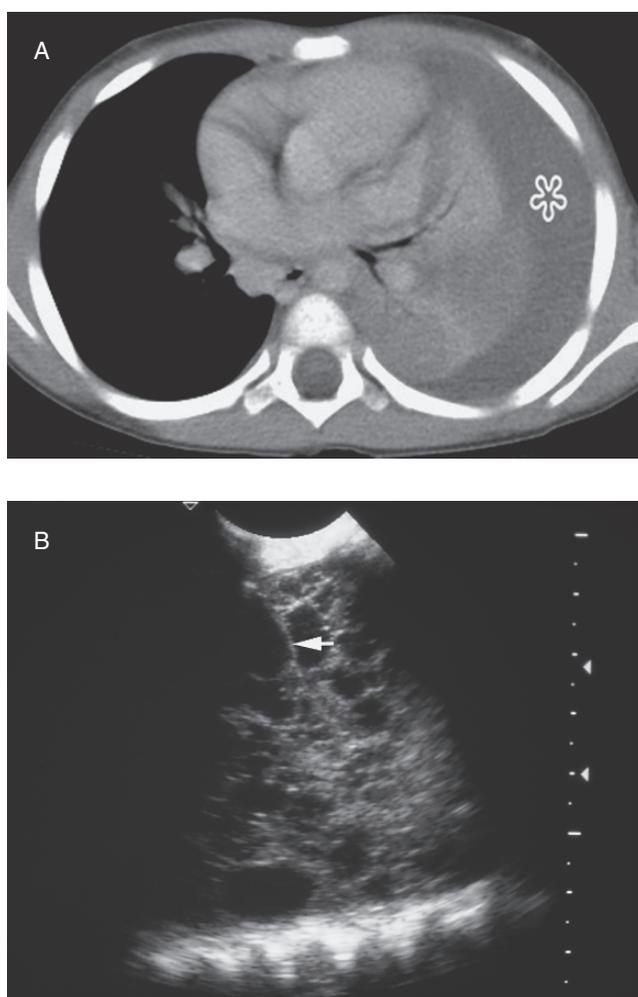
Percutaneous treatment of organized empyema. (A) Chest CT demonstrates left lower lobe pneumonia with large left pleural empyema (asterisk). (B) Sonogram of the left pleural empyema demonstrates grade 2 organization with large amount of organization with fibrin strands (arrow) separating purulent locules. (C) Chest radiograph following placement of 12-F pigtail catheter for fibrinolytic therapy and drainage. (D) Chest CT following fibrinolysis demonstrating resolution of the empyema with a trace amount of pleural thickening following therapy (arrow).
